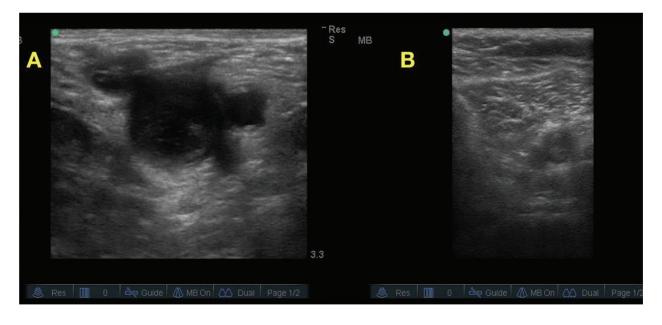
POCUS ultrasound demonstrates DVT of the left common femoral vein (A) and left popliteal vein (B) evident by the echogenic material within the lumen and non-compressible veins with graded compression.
